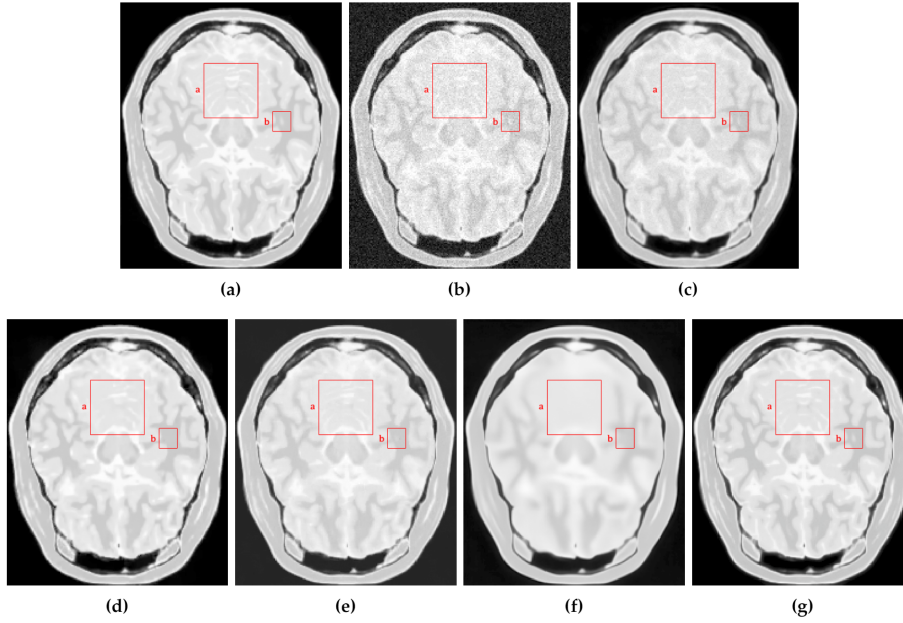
Comparison of the denoising methods on the PDw synthetic noise-free MR image corrupted with 5% Rician noise. (a) Original synthetic noise-free MR image. (b) Original image corrupted with 5% Rician noise. (c–g) are the denoising results of the KSVD, the PRINLM, the BM4D, the DnCNN and the NLSD, respectively.
